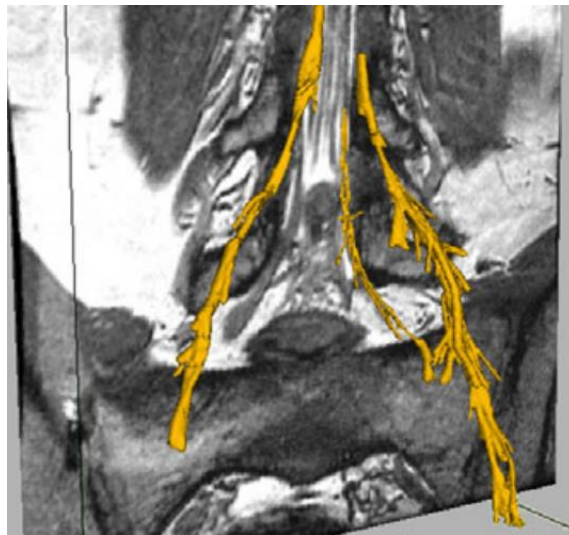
MRI model that segmented the hip nerve bundles for easier visualization [81]
